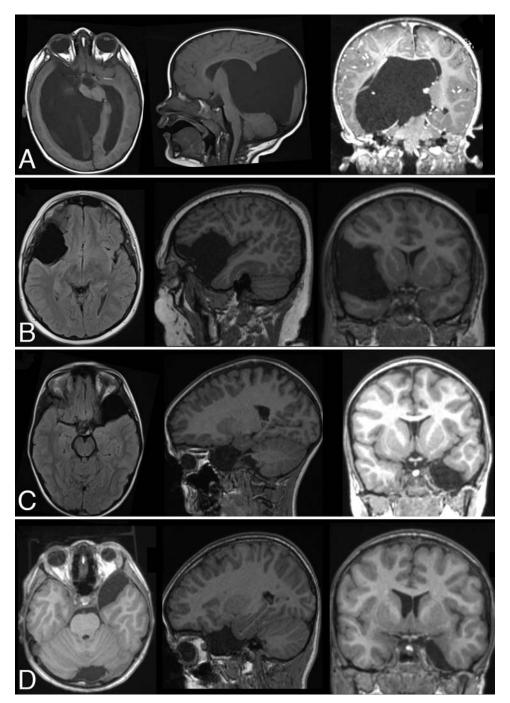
Axial, sagittal, and coronal T1-weighted MR images (without gadolinium enhancement, except for the coronal image in A) of 4 patients with an intracranial arachnoid cyst. A and B: Two patients with a calculated cyst size (anteroposterior × craniocaudal × mediolateral) of > 68 cm³, a 17-month-old boy (A) (960 cm³) and a 13-year-old boy (B) (192 cm³). Both patients underwent surgery, given their cyst-attributed symptoms/findings. C and D: Two patients with a calculated cyst size of < 68 cm³, a 7-year-old girl (C) (64 cm³) and a 9-year-old boy (D) (46 cm³). Both patients were asymptomatic and have not undergone surgery to date.
